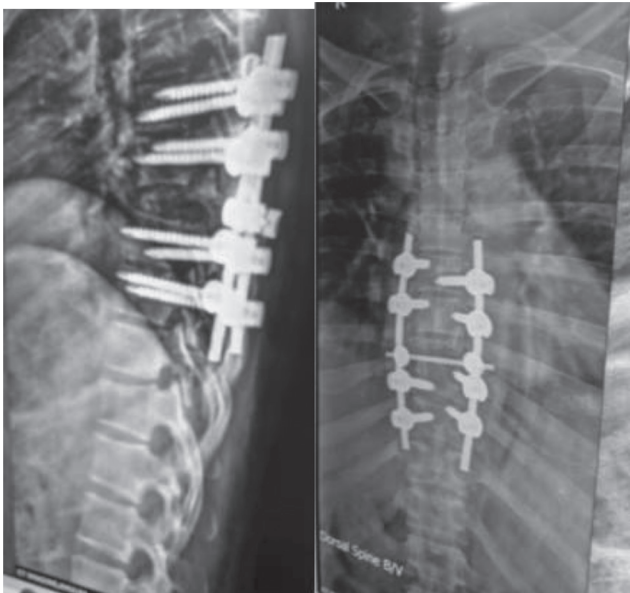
Postoperative X-ray, lateral and AP view.
